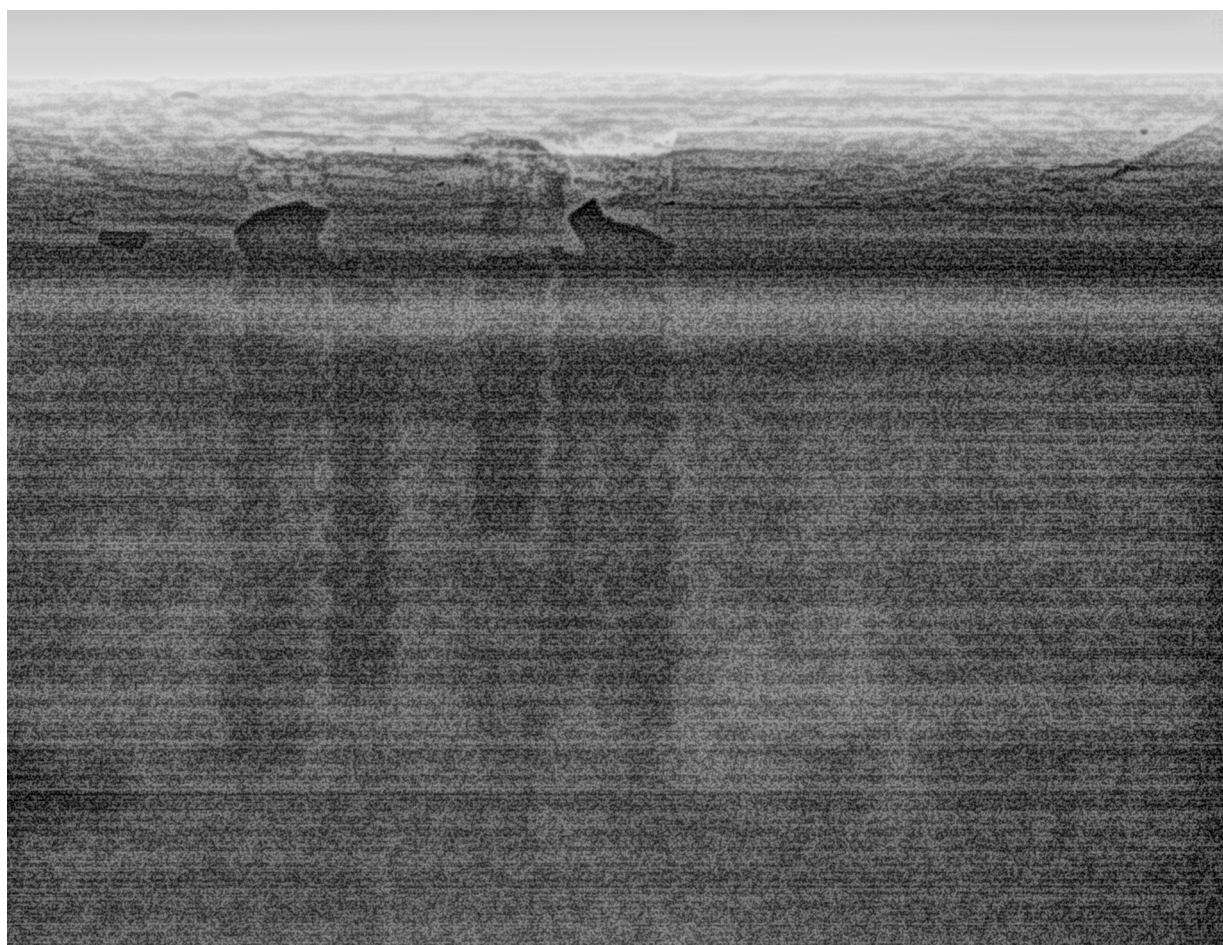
X-Ray image showing the presence of lower portions of broken screws within the bearer (courtesy of British Transport Police).
